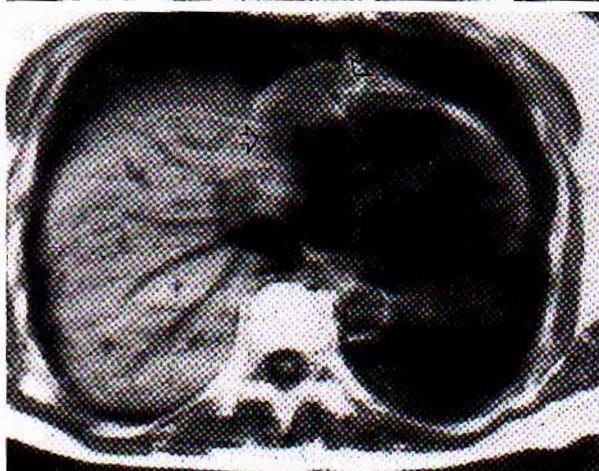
a: Postiodine CT scan shows hypodense lesion near the hepatic veins (solid arrow) and a second close to the right cardiac ventricle (open arrow). b: Strongly T1-weighted image (TR 400 ms; TE 26 ms) clearly shows the first lesion and its proximity to the adjacent parenchyma and hepatic veins (arrows). c: T1-weighted image with cardiac gating clearly shows the second lesion and its cardiac extension (open arrows), but the first lesion cannot be clearly seen due to the prolonged TR during cardiac gating.
